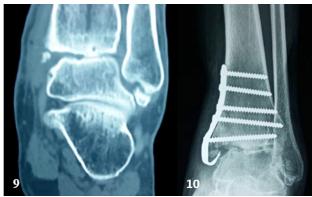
Patient 1. 23-year-old female patient with severe PTOA of the ankle, secondary to a Tibial Pilon Fracture. PTOA grade 4. CT and X ray before MSCs procedures.
